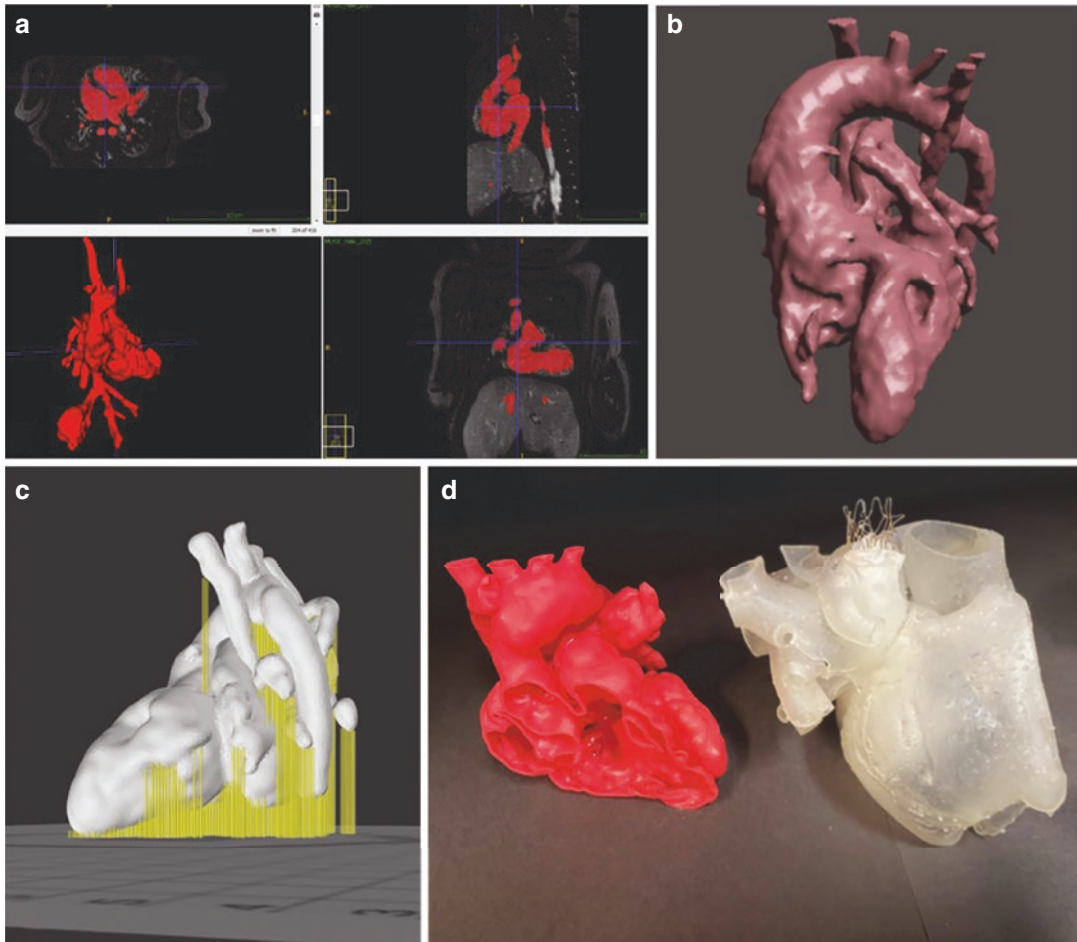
3D printing process. (a) Segmentation of contrast-enhanced cardiac MRI. (b) Virtual blood pool heart model created from segmentation. (c) Model on virtual printer bed with supports (yellow), ready to send to printer. (d)
